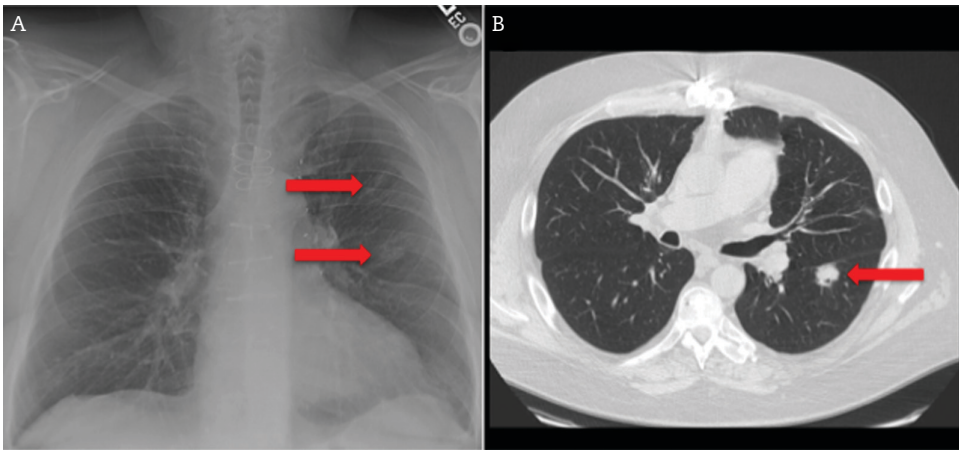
(A) Chest x-ray demonstrating two nodules in the upper and lower lobes of the left lung. (B) Chest computed tomography image demonstrating a nodular density in the superior segment of the left lower lobe.
